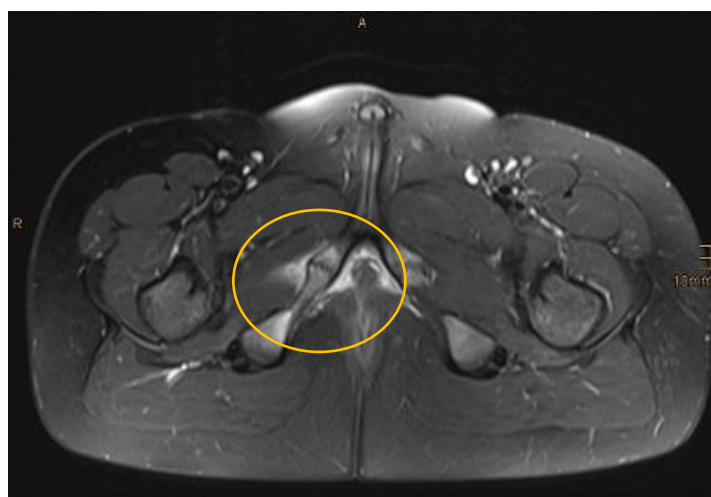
MRI of the pelvis.
